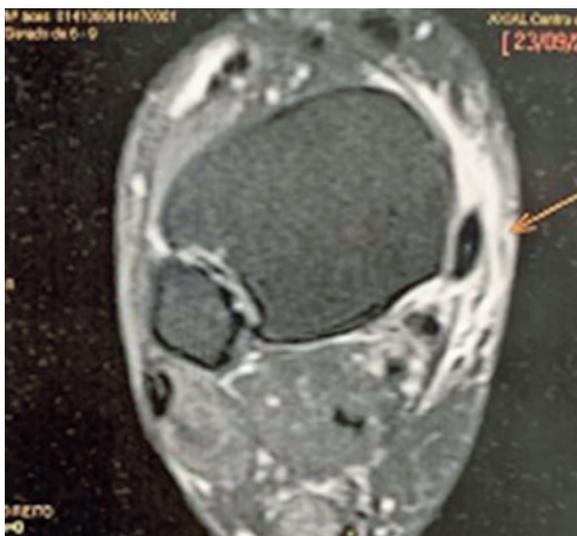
Ankle magnetic resonance imaging showing the posterior tibialis tendon located anteriorly to the retromalleolar groove.
